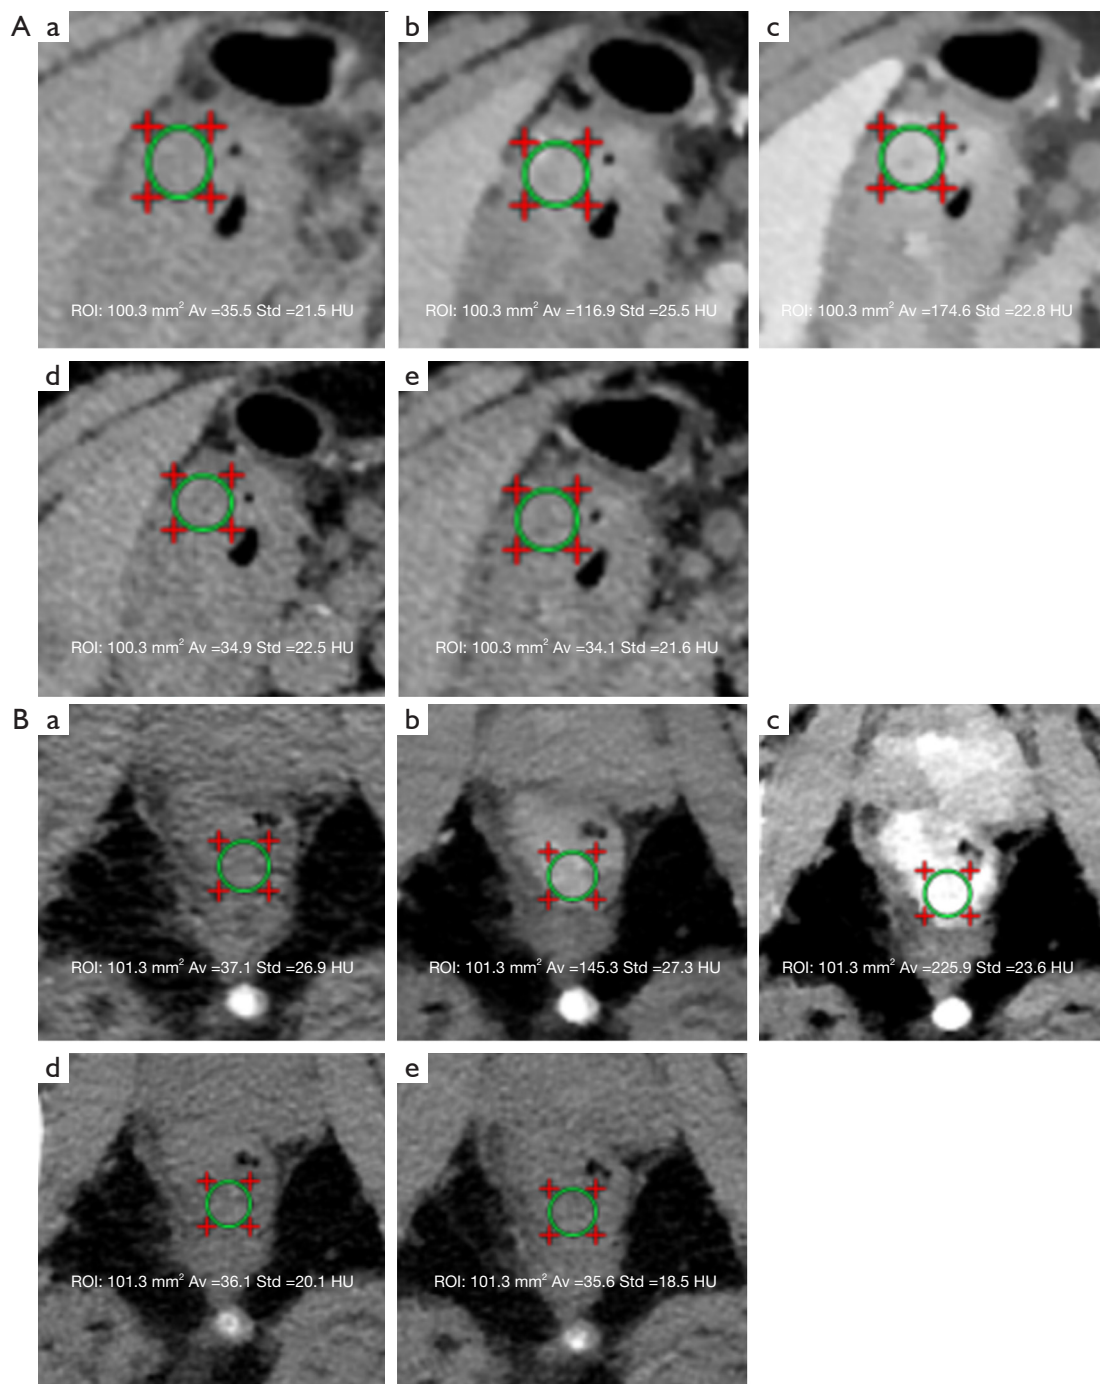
Images showing differences in CT numbers in the region of the colorectal tumor [(A) colon tumor; (B) rectal tumor]. (a-e) The TNC, arterial phase, portal venous phase, VNCa, and VNCp images, respectively. ROI, region of interest; Av, average; Std, standard deviation; CT, computed tomography; TNC, true non-contrast; VNCa, virtual non-contrast image from the arterial phase; VNCp, virtual non-contrast image from the portal venous phase; HU, Hounsfield units.
